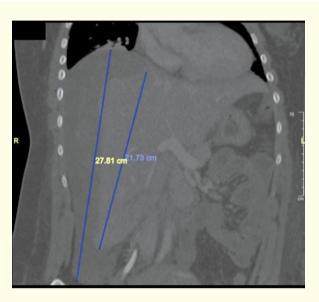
CT scan demonstrating the subcapsular liver hematoma from a para sagittal view.
